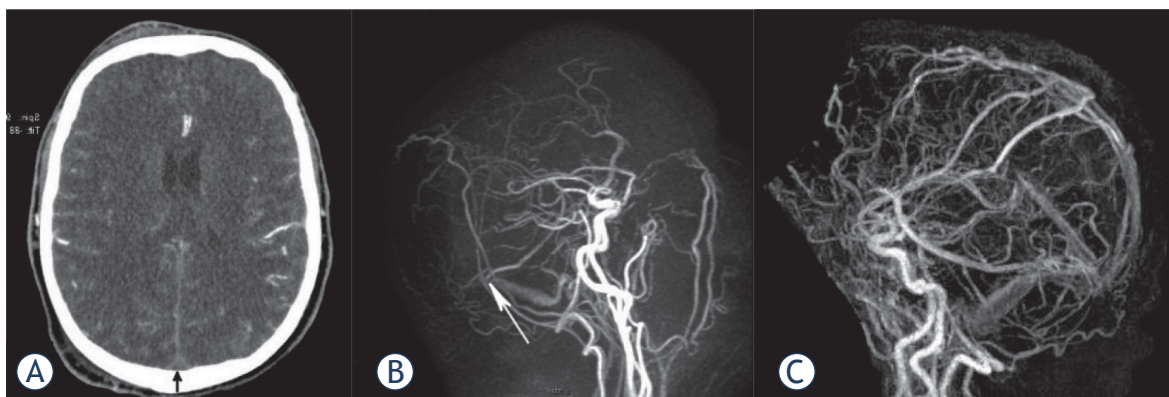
A 59-year old man was examined after 5 days of headaches and a seizure. CT revealed bilateral cortical subarachnoid hemorrhage (SAH) and moderate diffuse brain edema, but no hemorrhagic infarction was formed (A). An extensive thrombosis of cerebral sinuses/veins including the superior sagittal sinus, transversal sinuses, left sigmoid sinus and jugular bulb was observed. The right transversal sinus was occluded to the point of Labbe vein inflow (B), arrow showing confluence of vein to sinus). Fractured heparin and later warfarin were introduced; the patient scored 0 according modified Rankin Score (mRS) at control examination. Complete recanalization of the occluded sinuses occurred (C).
